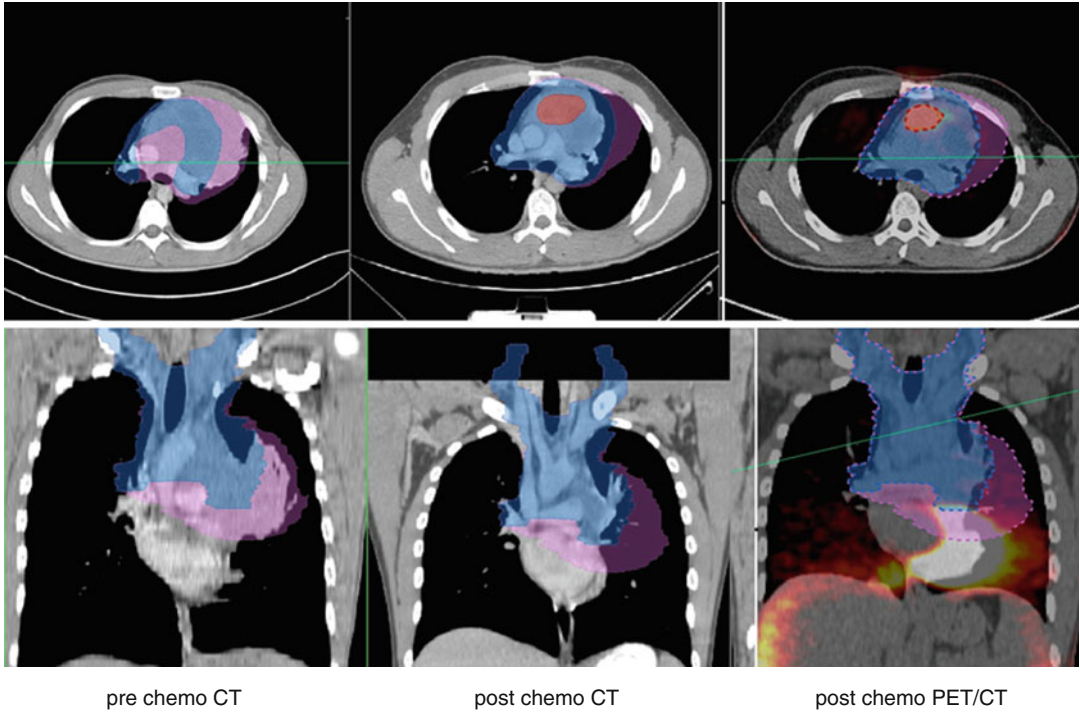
PTV Phase I delineation using PET/CT findings
